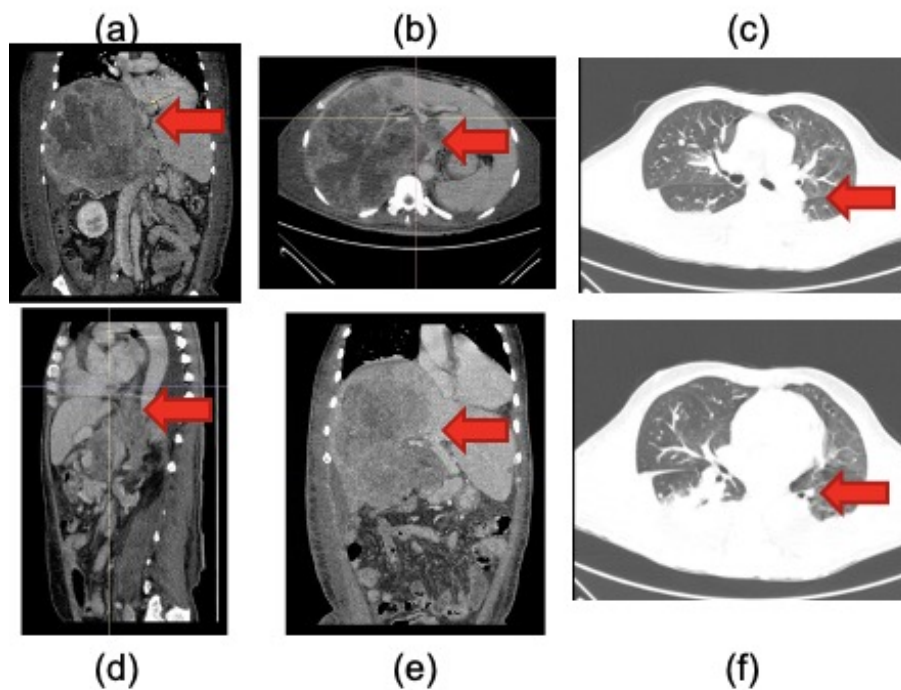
Radiographic findings from upper abdominal multiphasic CT-scan demonstrated a large hepatic lesion [(a), (b)] with the involvement of portal vein [(d), (e)] and extrahepatic manifestation [(c), (f)].
